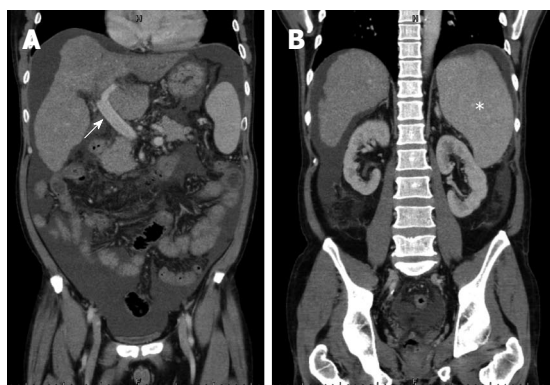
Preoperative computed tomographic findings of case 1. A: Enlarged portal vein of 1.8 cm in diameter (white arrow); B: Splenomegaly with 15.4 cm at the longest axis without remarkable collaterals (white asterisk).
